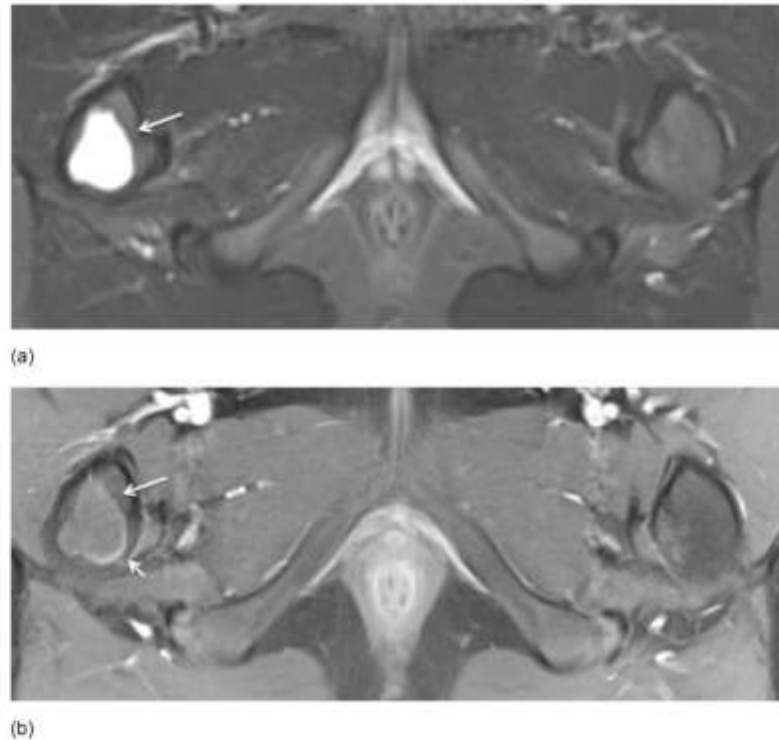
(a-b) Axial STIR and axial fat saturated T1-weighted MR image after IV Gd in a 9-year-old boy. Simple bone cyst was seen as a well-demarcated metaphyseal STIR hyperintense lesion (arrow) and T1 hypo-intense lesion (arrow) with minimal rim enhancement (short arrow) in the right femur.
